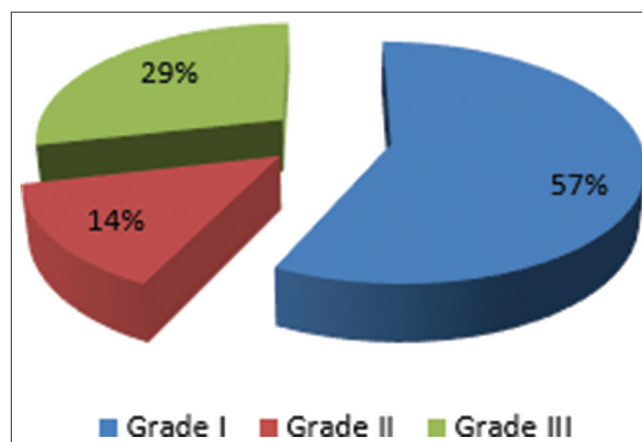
Grading of lung involvement by CT chest scoring
